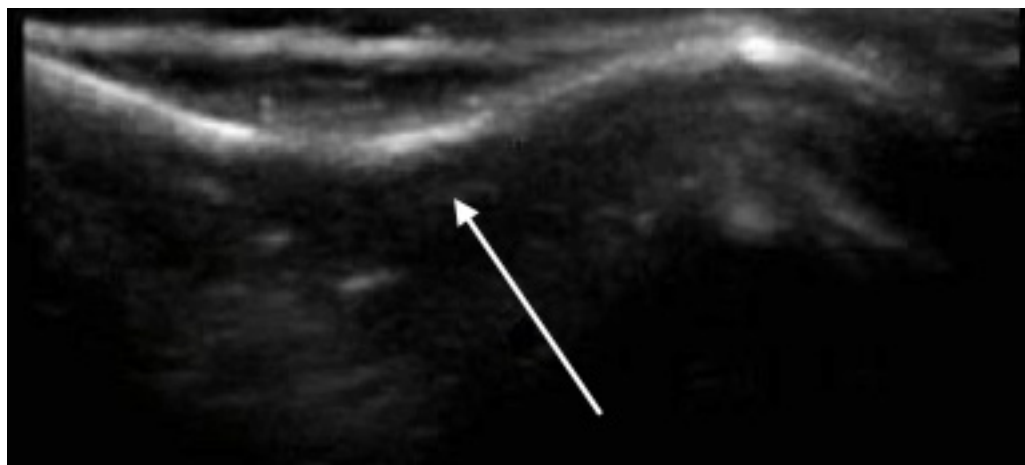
Point-of-care ultrasound demonstrating “ping pong” skull fracture (Image obtained using a liner probe, 13-6 megahertz).
